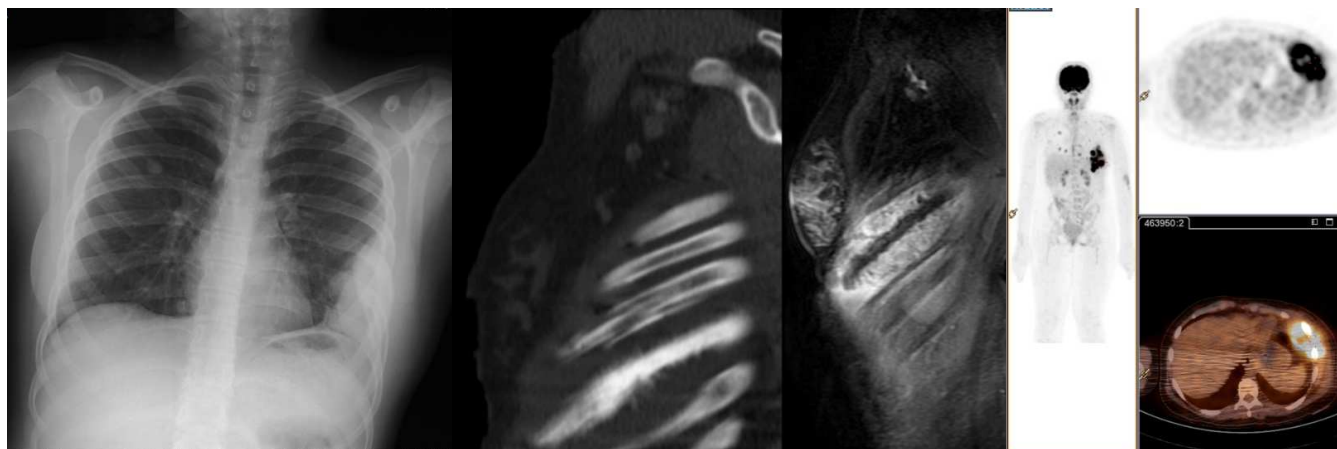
A 15-year-old girl with a history of hypoparathyroidism and hypercalcemia presented with 2 days of left costal pain, stiffness, and tremor of the left upper limb lasting minutes. Chest X-ray showing a solid costal lesion in the left hemithorax. Multiple pulmonary nodular lesions are consistent with metastases.
